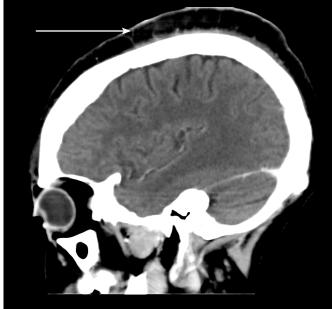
CT image of the scalp demonstrating a large subgaleal abscess with surrounding cellulitis
